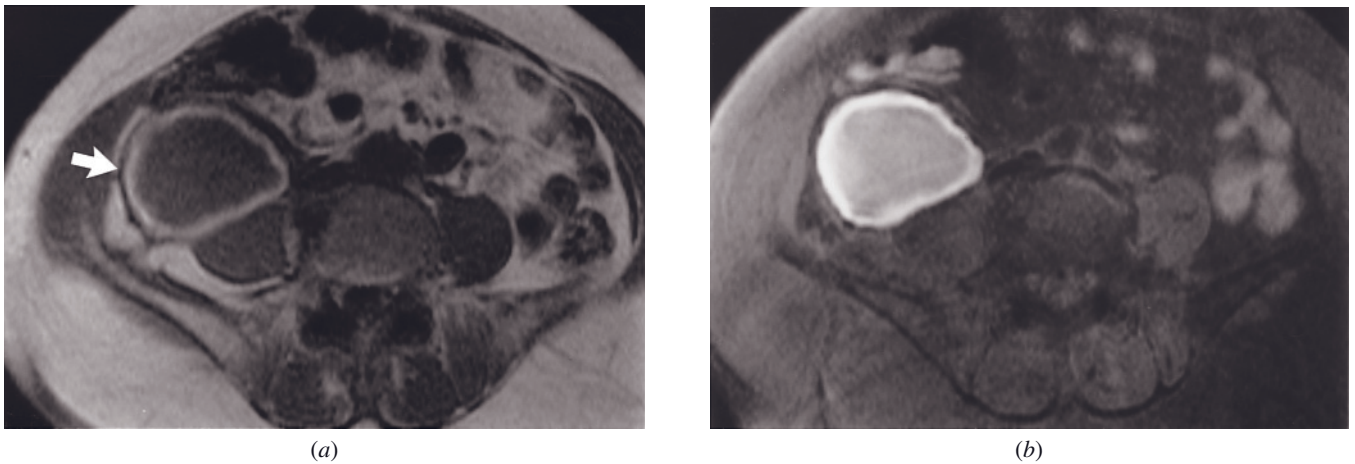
Retroperitoneal hematoma. SGE (a), fat-suppressed T1-weighted spin-echo (b), and interstitial-phase gadolinium-enhanced SGE (c) images. A 7.5-cm well-defined hematoma (arrow, a) is noted along the anterior margin of the right psoas muscle. The periphery of the hematoma is hyperintense on the precontrast SGE image (a). The hyperintensity is markedly accentuated on the T1-weighted fat-suppressed spin-echo image (b), confirming that fat is not the cause of hyperintensity. A thin rim that is low in signal intensity on both T1- and T2-weighted (not shown) images reflects the presence of hemosiderin and suggests chronicity of the hematoma. After gadolinium administration, no enhancing tissue components are identified in the hematoma (arrows, c), which excludes tumor as the cause.
